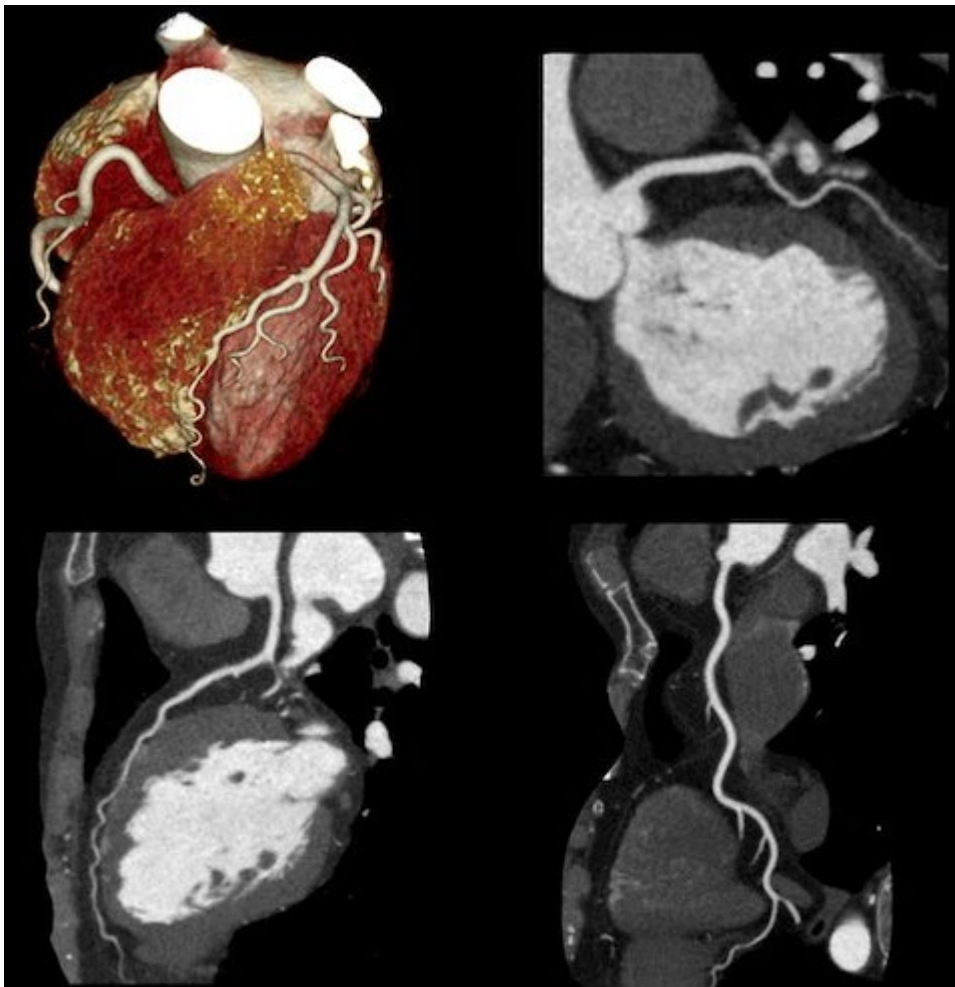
Cardiac coronary computed tomography angiography (CCTA) exam showing different views of the myocardium and the coronary arteries (ITN, 2020).
